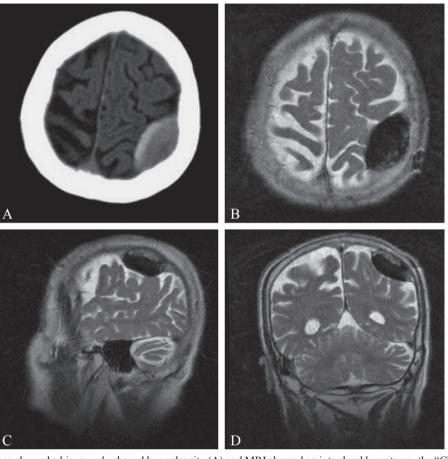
Case 1. CT scan showed a biconvexly shaped hyperdensity (A) and MRI showed an interdural hematoma, the "Chinese Dumpling" view (B-D).
